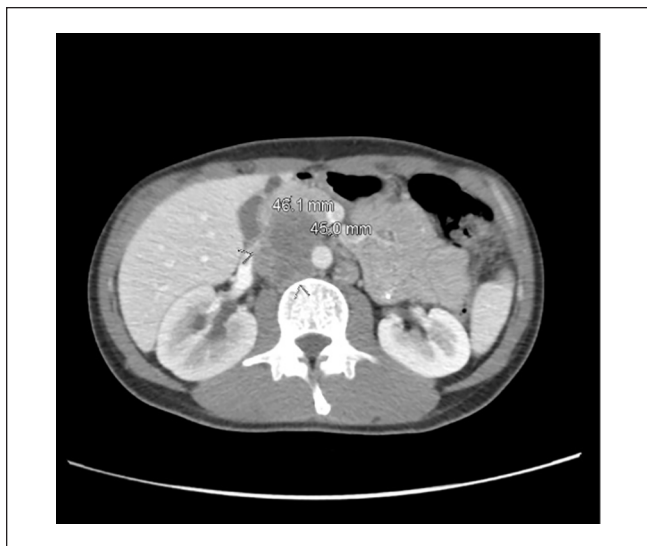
Axial computed tomography (CT) scan of the abdomen and pelvis with contrast showing retroperitoneal lymphadenopathy below the right renal hilum resulting in compression of the right renal vein. Right-sided hydronephrosis is also present.
